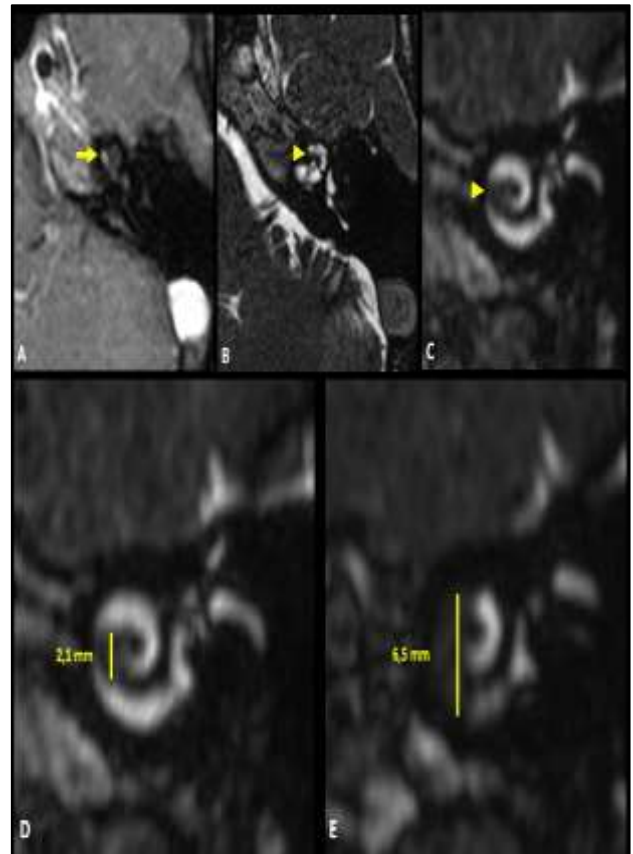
(A-E): Intracochlear schwannoma in second turn of left cochlea. Axial fat-saturated gadolinium-enhanced T1-weighted image and balanced fast field-echo image through the scala tympani and parasagittal balanced fast field-echo reconstruction. Enhancing schwannoma in scala tympani (yellow arrow). Normal hyperintense fluid signal intensity inside scala vestibuli and obliteration of scala tympani in anterior part of second turn (yellow arrowhead). Inside scala vestibuli in basal turn (red arrow). Invasion of scala tympani and scala vestibuli in anterior part of second turn (red arrowhead). Obliteration of scala tympani in upper part of second turn and mainly of scala vestibuli (curved red arrow), without extension to vestibule. Schwannoma in basal turn and anterior part of second turn (red arrowheads). Fluid signal intensity is still present in posterior part of scala tympani (red arrow). Intracochlear schwannoma with a 5-year MR follow-up. Parasagittal balanced fast field-echo reconstruction images through left cochlea. Initial image with small 2.1 mm schwannoma in scala tympani anterior part of second turn. After 5 years, further growth (6.5 mm) to basal turn, scala vestibuli, and anterior part of second turn.
